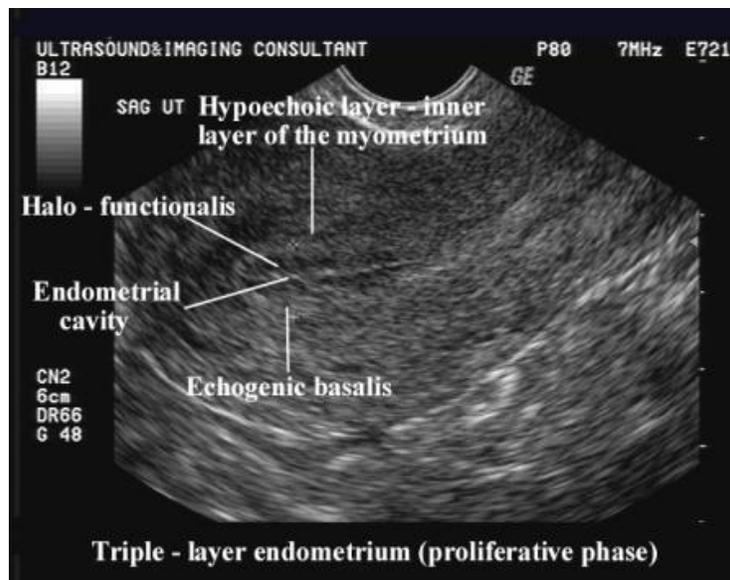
Ultrasound review reveals myometrial, endometrial and sub endometrial zones. (Pin by Gtouchantzidis on uterus ...pinterest.com)
